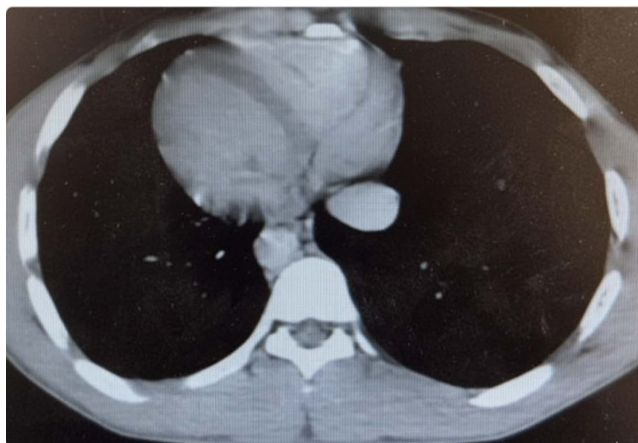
High-resolution chest computed tomography scans showing complete reversal of heart and great vessels.
